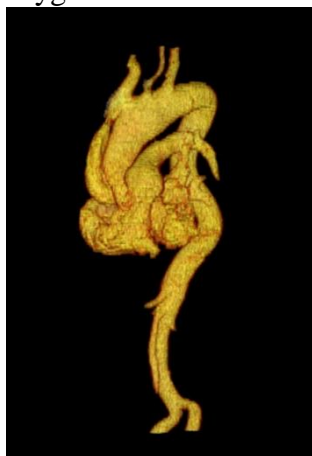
CT-scan revealed the presence of a hematoma surrounding the aortic arch, without signs of rupture or active bleeding
